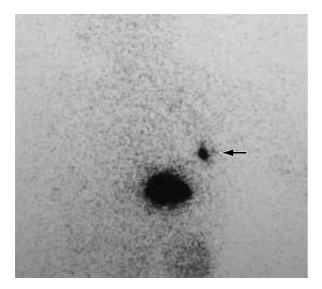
Visualization of sentinel lymph node by lymphoscintigraphy Radioisotopes administered in the region of tumor are carried through the lymph duct and accumulated in a sentinel lymph node. The radioisotopes are then detected by a gamma probe.
